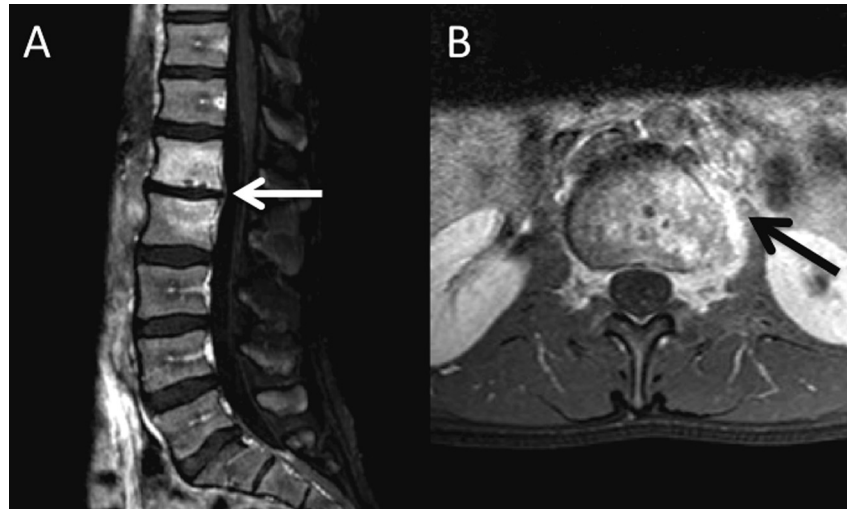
Gadolinium-enhanced T1-weighted magnetic resonance imaging (MRI) examination, 11 weeks after the assault. (A) Sagittal view: increased signal intensity in L1-L2 vertebral bodies (arrow). (B) Axial view: infiltration of soft paravertebral tissues on the left (arrow).
